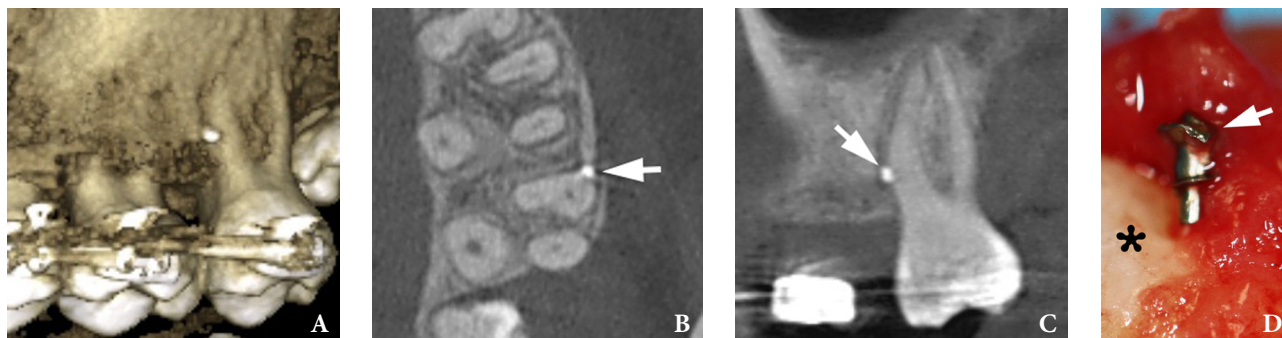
Cone beam CT scans (A: 3D reconstructed; B: axial; C: panoramic) shows fractured tip of microimplant (arrows) and its incorrect positioning into the tooth ligament. (D) Tip (arrow) of the fractured microimplant after removal (magnification, $\times 10$) simultaneously with supernumerary tooth 2.9 (asterisk: crown of the removed tooth 2.9).
